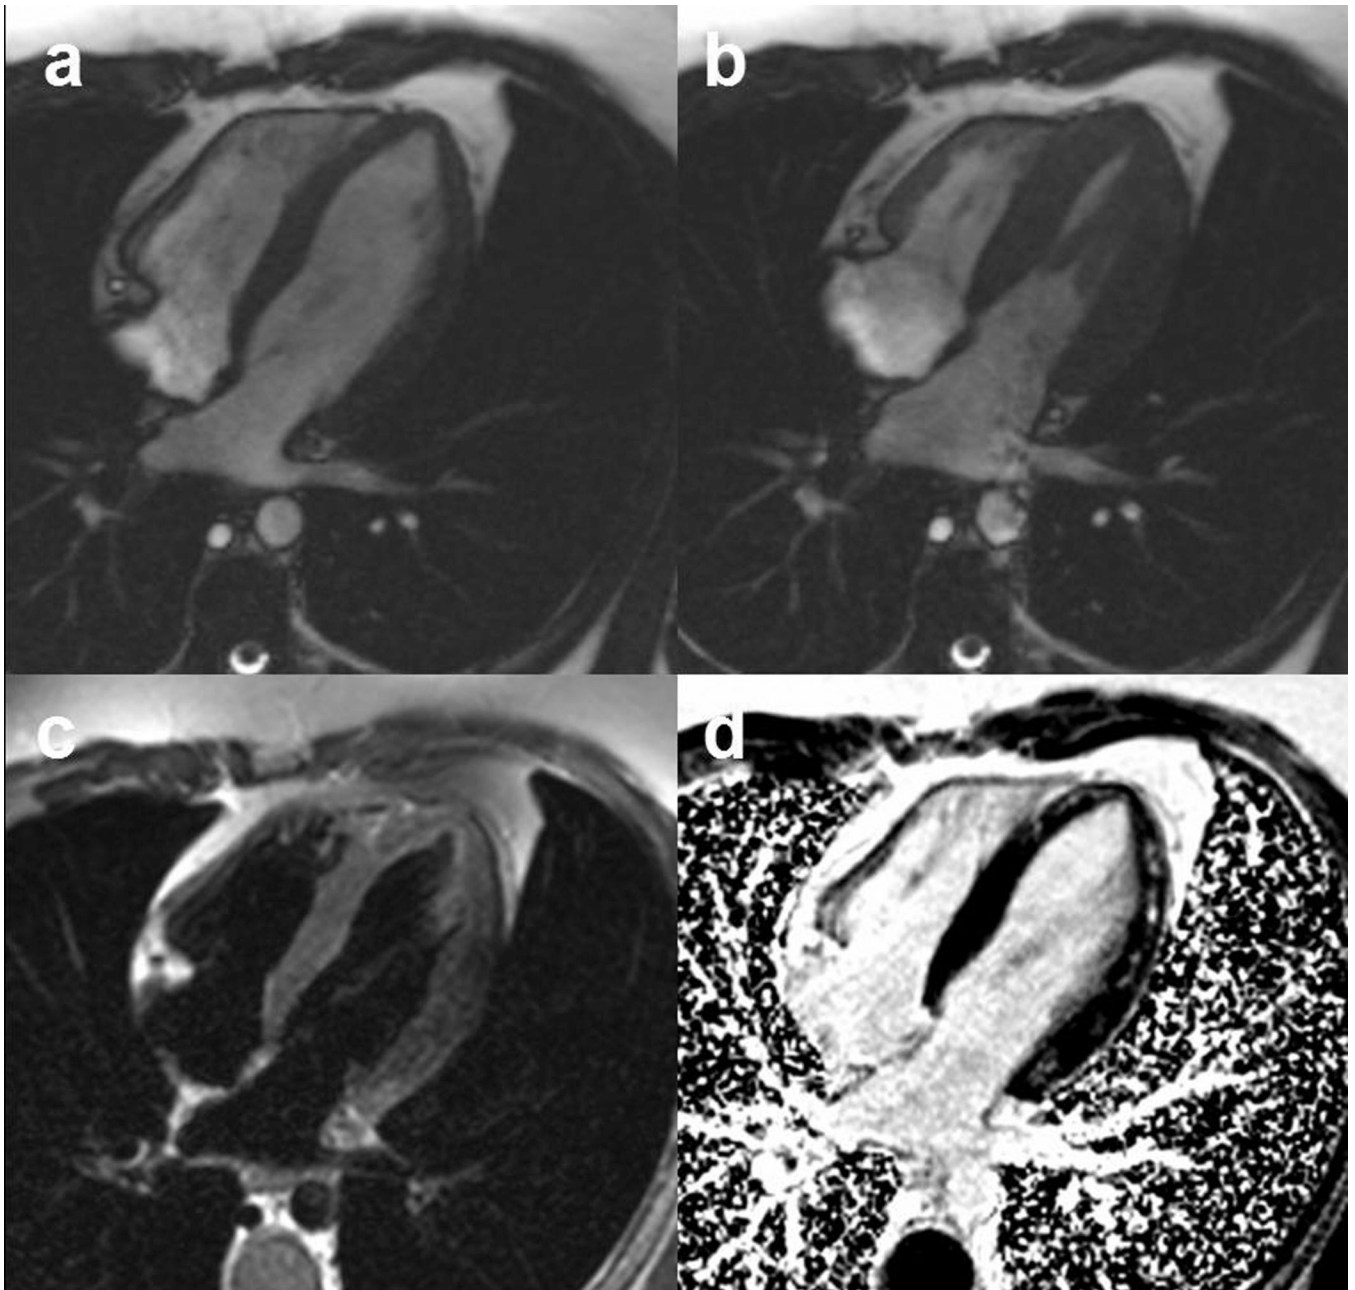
CMR images from a 20 yo M admitted to an outside hospital with myocarditis who returns with recurrent chest pain. Cine SSFP images at (a) end diastole and (b) end systole demonstrate preserved systolic function. Edema imaging with (c) T2-weighted TSE does not show acute edema. Delayed enhancement images (d) demonstrate focal mid-wall scar in the lateral wall and apical-septal walls consistent with the clinical history of recent myocarditis.
